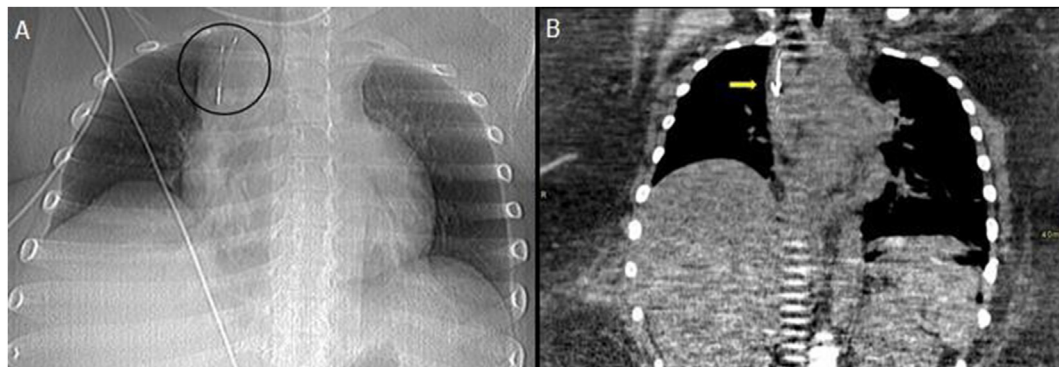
A.- Chest CT Scout image shows the upper struts in the superior vena cava (black circle). B.- Coronal view of chest CT without contrast shows upper struts in the superior vena cava (yellow arrow).
